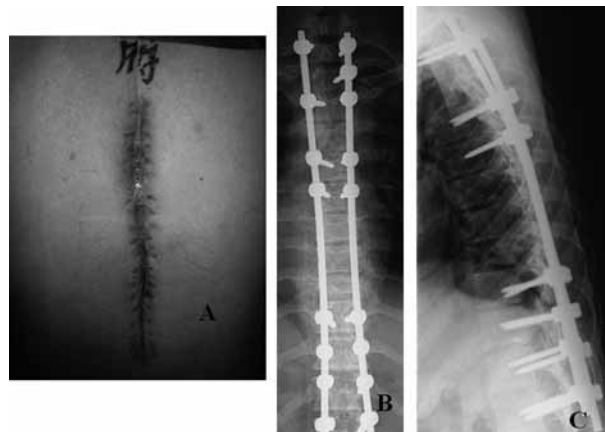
Case 1 : Clinical aspect and radiograph 6 months after application of VAC device.
